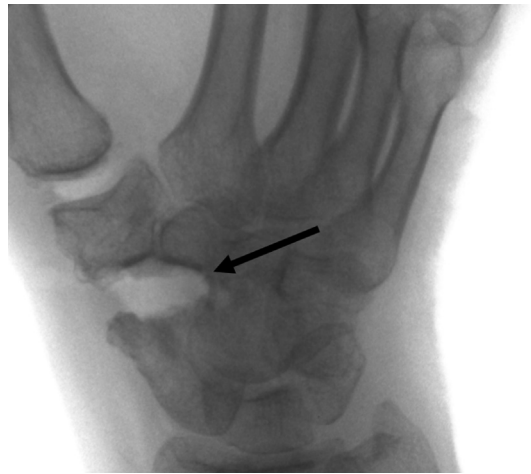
Intraoperative radiograph of a right hand after an arthroscopic resection arthroplasty for STT arthritis. The arrow points toward the radial aspect of the capitate that remained intact, showing that a selective débridement has been performed.
